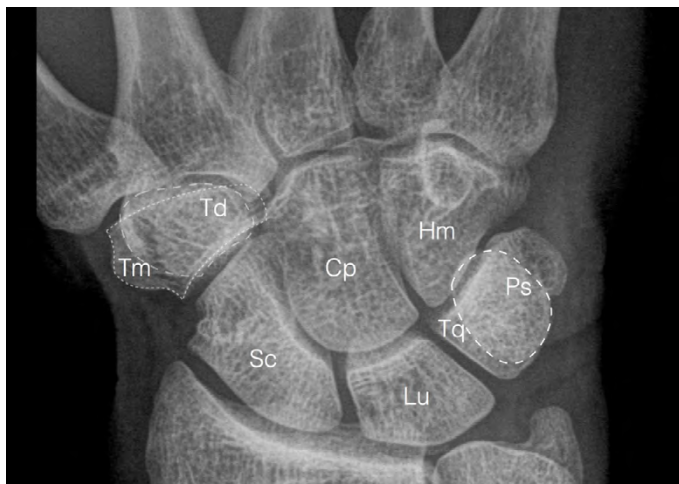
X-ray of the wrist (p-a view). Marks. Distal row, from the left: Tm — trapezium bone, Td — trapezoid bone, Cp — capitate bone, Hm — hamate bone. Proximal row, from the left: Sc — scaphoid bone, Lu — lunate bone, Tq — triquetrum bone, Ps — pisiform bone.
